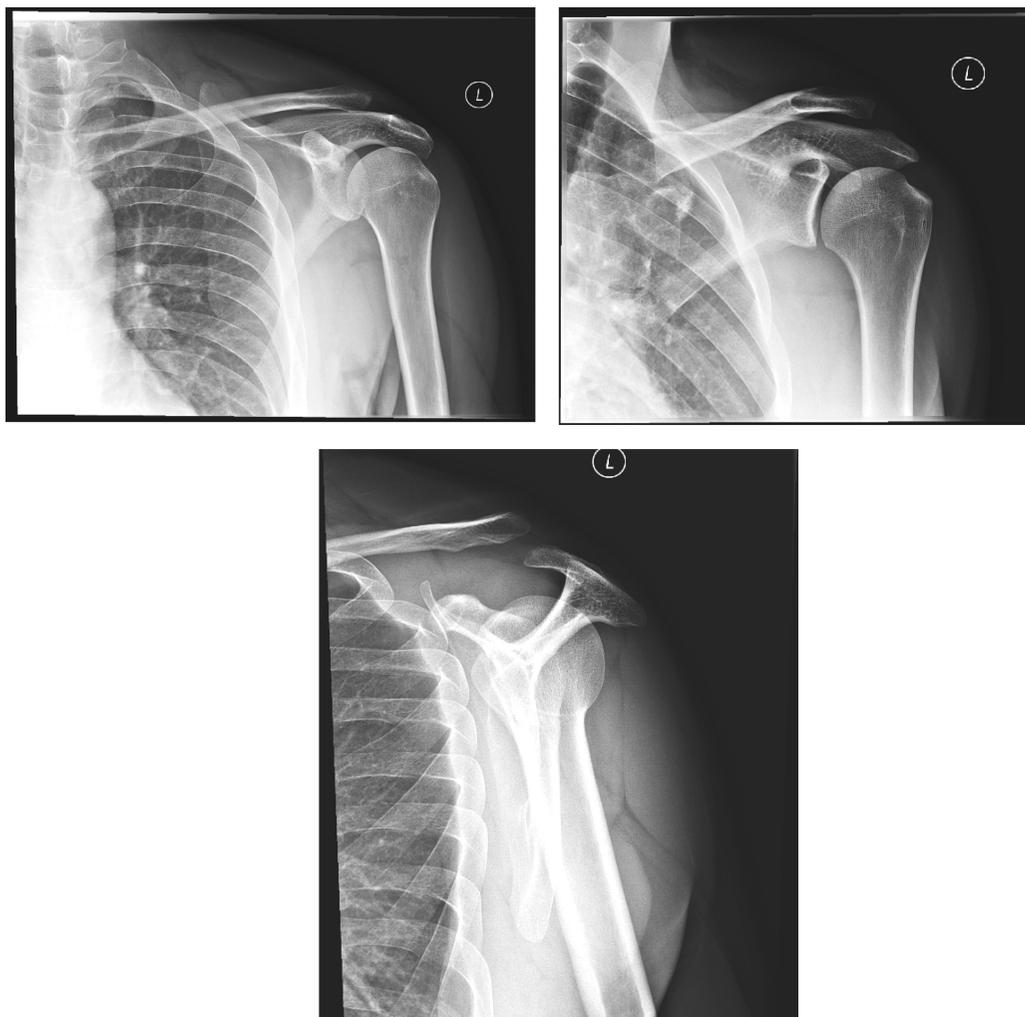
Radiographs—anteroposterior, Grashey, and Y-views of the left shoulder. Note widening of the acromioclavicular joint with superior displacement of the clavicle.
